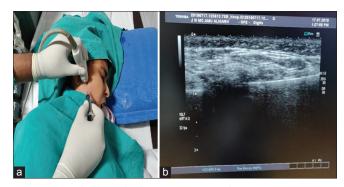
(a) Platelet-rich plasma injection in the superior joint space of the right temporomandibular joint guided by the ultrasonography (USG), (b) intraoperative USG shows 24 G needle in the right superior joint space
